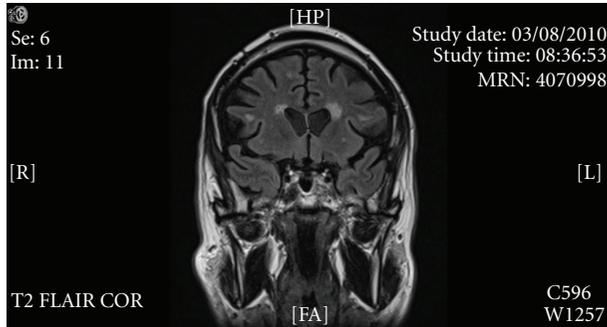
Periventricular and subcortical white matter hyperintensities. MRI, T2-weighted sequence, flair.
